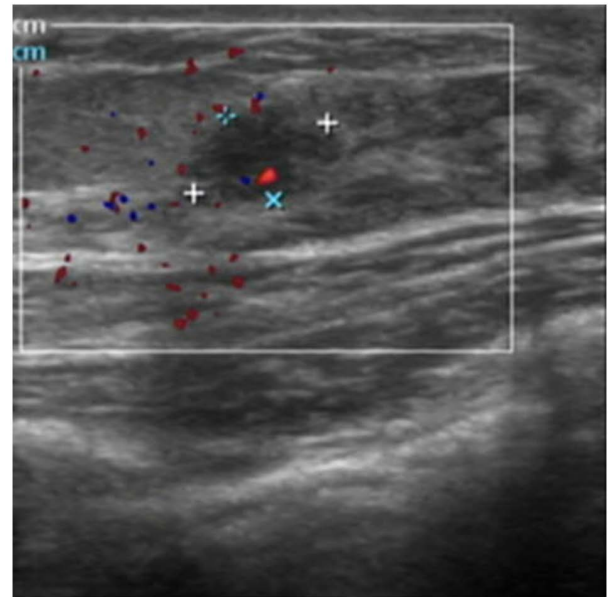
A 35-year-old woman without PND who underwent bilateral breast ultrasonography. Post-operative pathology showed presence of IDP in right breast. US demonstrates a low echoic tumor in right breast, the lesion size is 0.87x0.56 cm.
